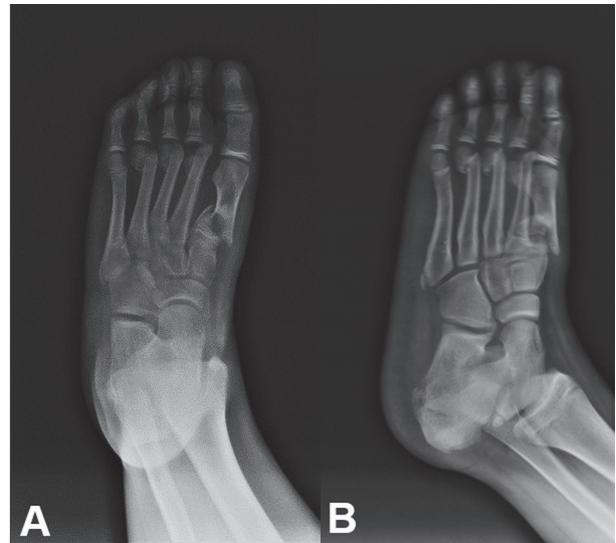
Traumatic lesions of midfoot with displaced fracture at the base of the I metatarsus (A), and of metatarsal heads of II, III, IV bone (B). X-ray examination is partly limited by poor patient collaboration
